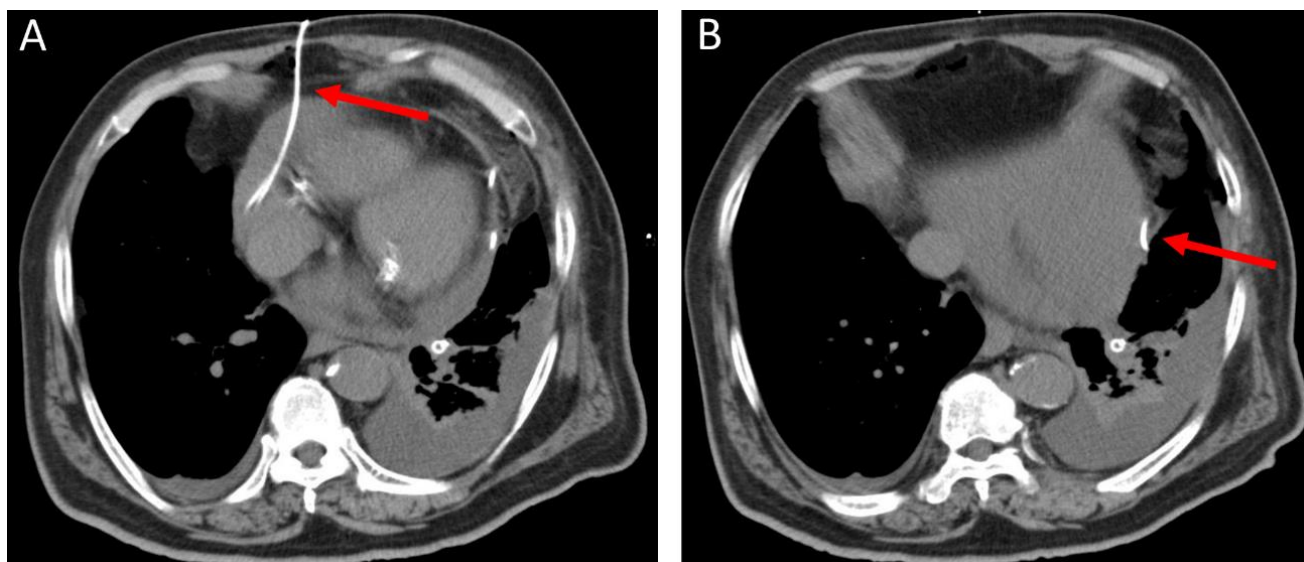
Post-procedural computed tomography imaging. (A, B) A drainage catheter (arrows) was successfully positioned within the pericardial cavity and the pericardial effusion was removed.
